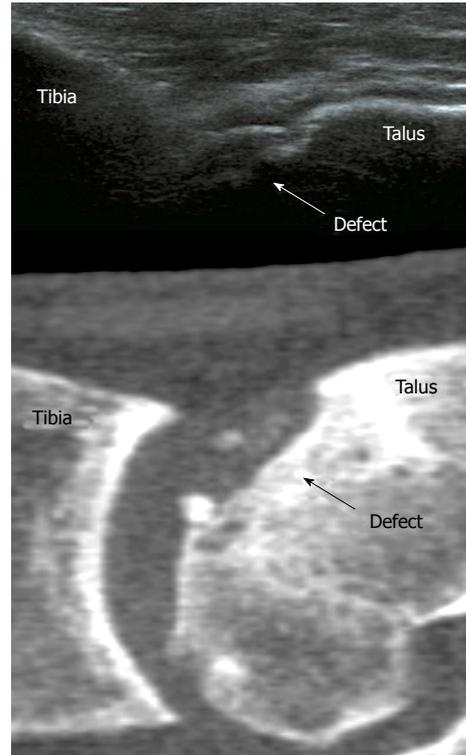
Ultrasound image (top) showing an osteochondral talar defect. A computed tomography scan (bottom) is shown for comparison.
